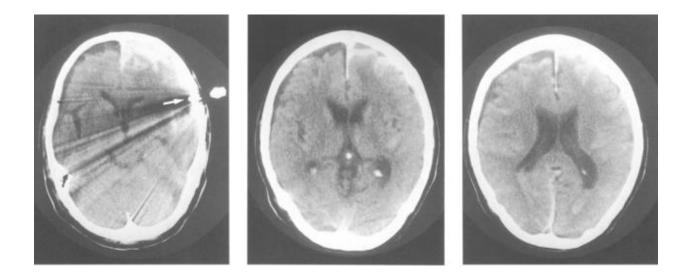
shows CT scans taken 12 hours after starting to drain the blood from the brain using a needle inserted into the space between the brain and the covering of the brain (the subdural space). The scans indicate a clear decrease in the amount of blood outside the brain. While the bruise on the brain remained the same, the shift of the brain's central line almost disappeared.
